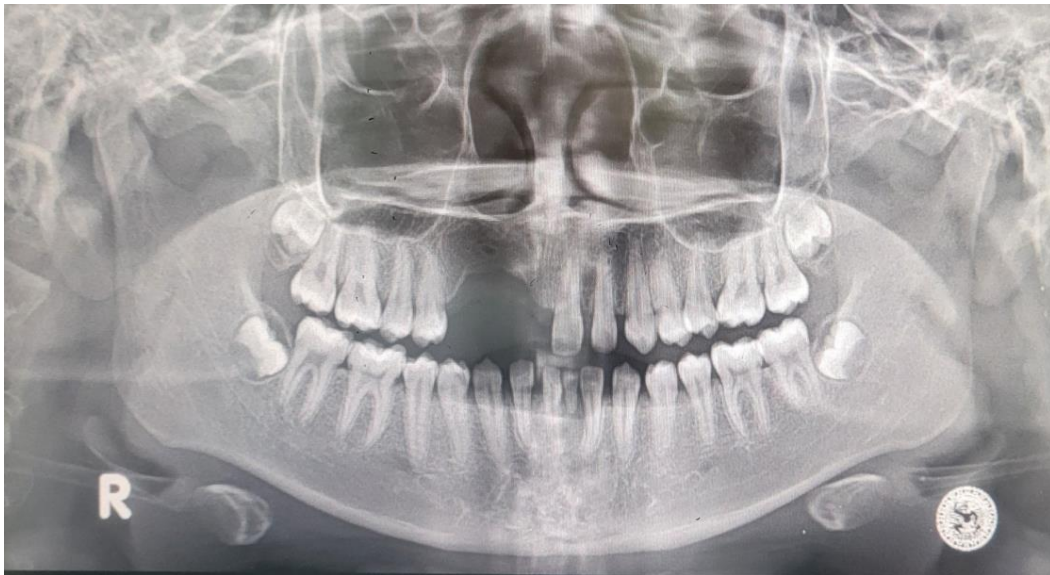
Postoperative panoramic radiograph, in the region of the right anterior maxilla.
